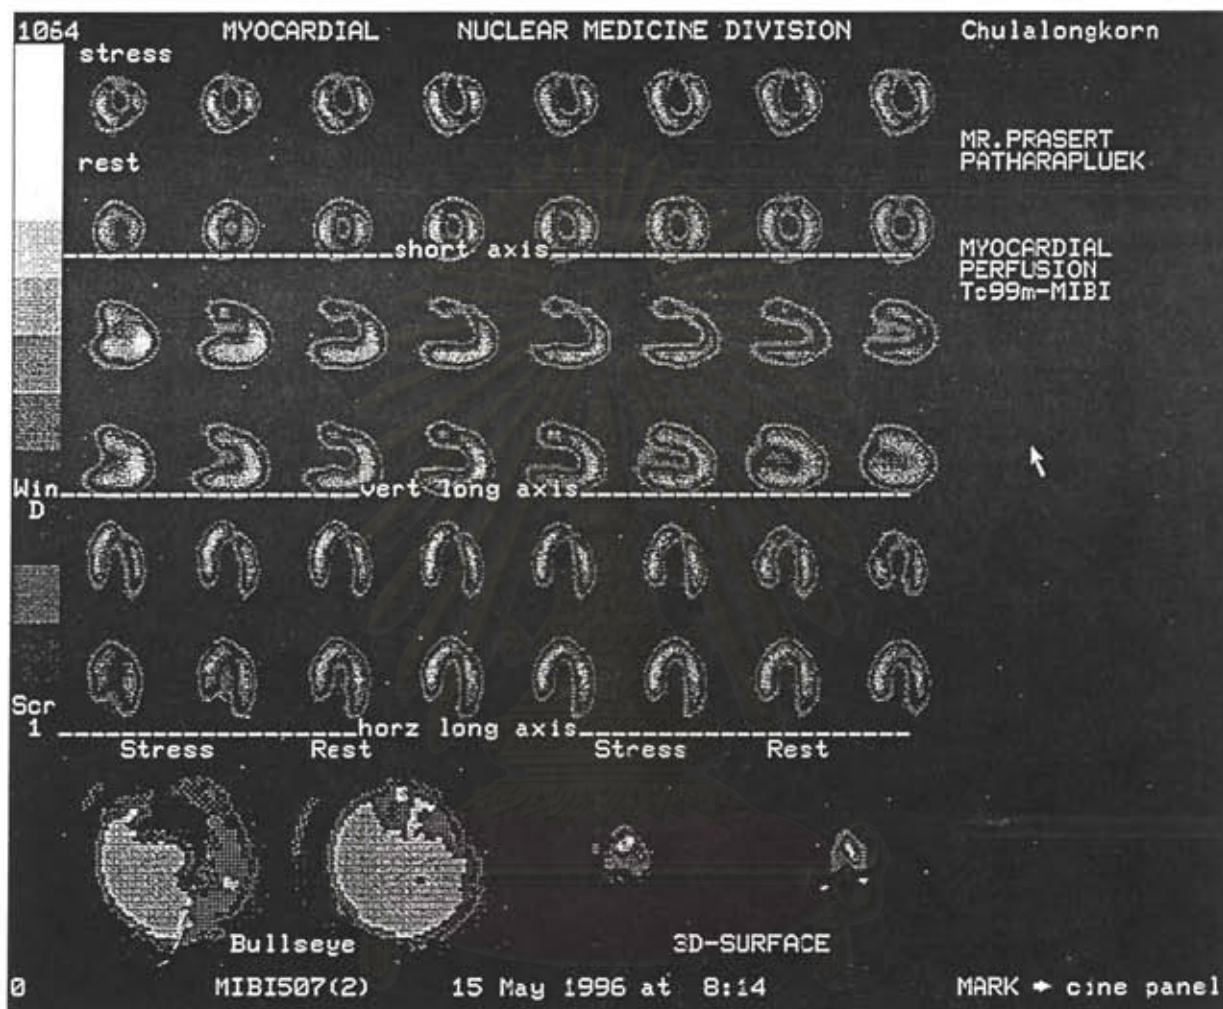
Stress and rest Tc-99m Sestamibi SPECT imaging after PTCA month 3 showing much improvement of myocardial ischemia at the anterior and apical wall
